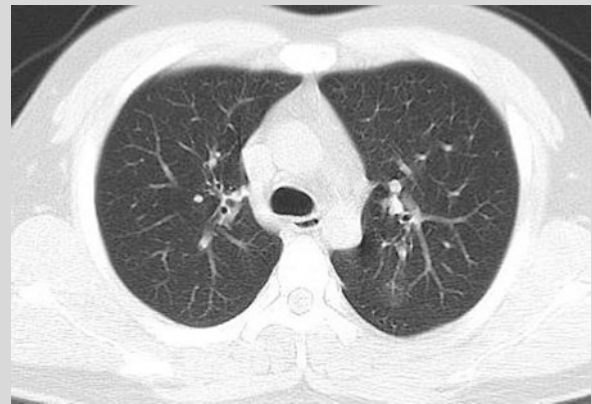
CT scan showed small flakes of ground glass opacity near the oblique fissure in the left upper lung lobe
